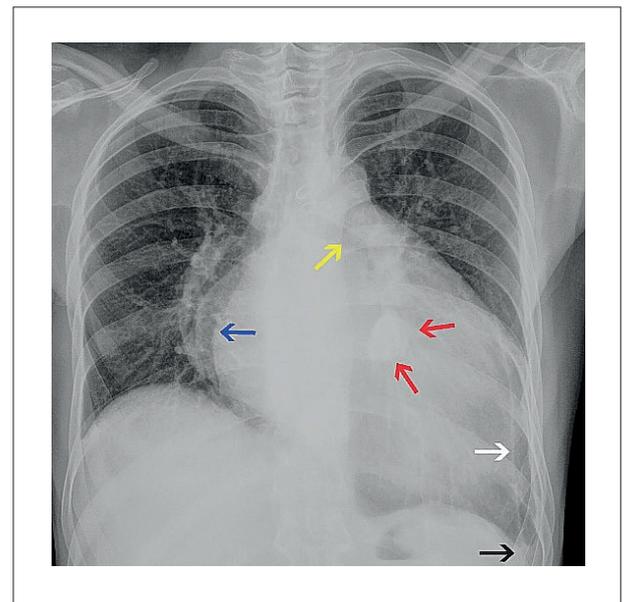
Chest radiography – posteroanterior view. Enlarged heart. Next to the mitral valve, there is an ovoid hyperdense lesion (red arrows) measuring about 3,5cm x 2,0cm. The double density sign (blue arrow) and elevation of the left bronchus (yellow arrow) indicate left atrial enlargement. The left costodiaphragmatic recess is obliterated (black arrow), and a calcified line is noted at the left hemithorax seemingly along the pleura (white arrow).
